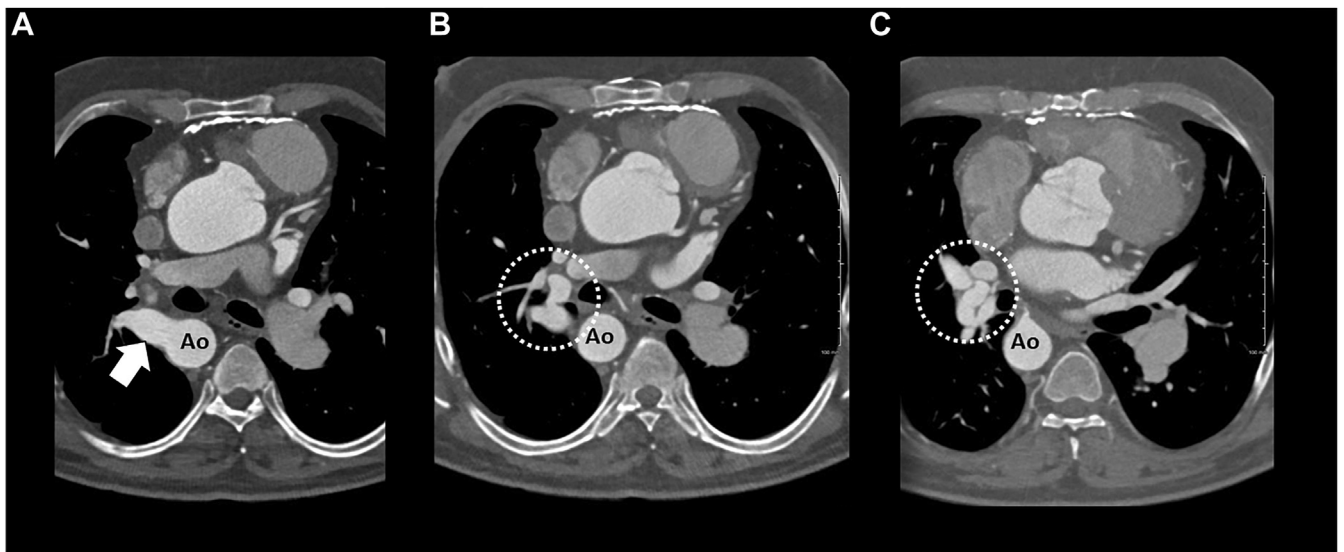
Major aortopulmonary collaterals in tetralogy with pulmonary atresia. Sequential axial slices from gated cardiac computed tomography. (A) A large aortopulmonary collateral (arrow) is seen to emerge from the proximal descending thoracic aorta (Ao). (B and C) The vessel takes a tortuous path (dotted circles) as it heads towards the mediastinum, from where it will travel out to supply a lung segment (not shown).
